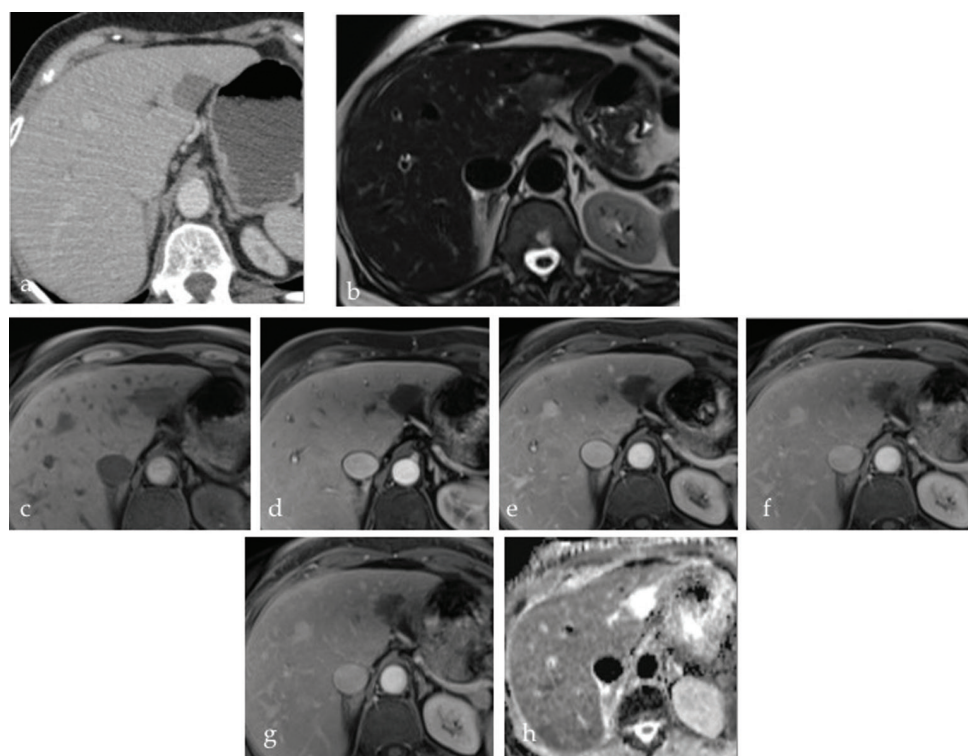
Sclerosed haemangioma. a. Computed tomography shows a hypodense lesion resembling a cyst, but is not T2 bright on (b) magnetic resonance imaging. c–g. Pre- and post-contrast multiphase magnetic resonance imaging does not demonstrate the typical pattern of haemangioma. h. Apparent diffusion coefficient map shows no restriction of diffusion. The lesion was biopsied and proven to be a sclerosed haemangioma, which can have variable appearance.
